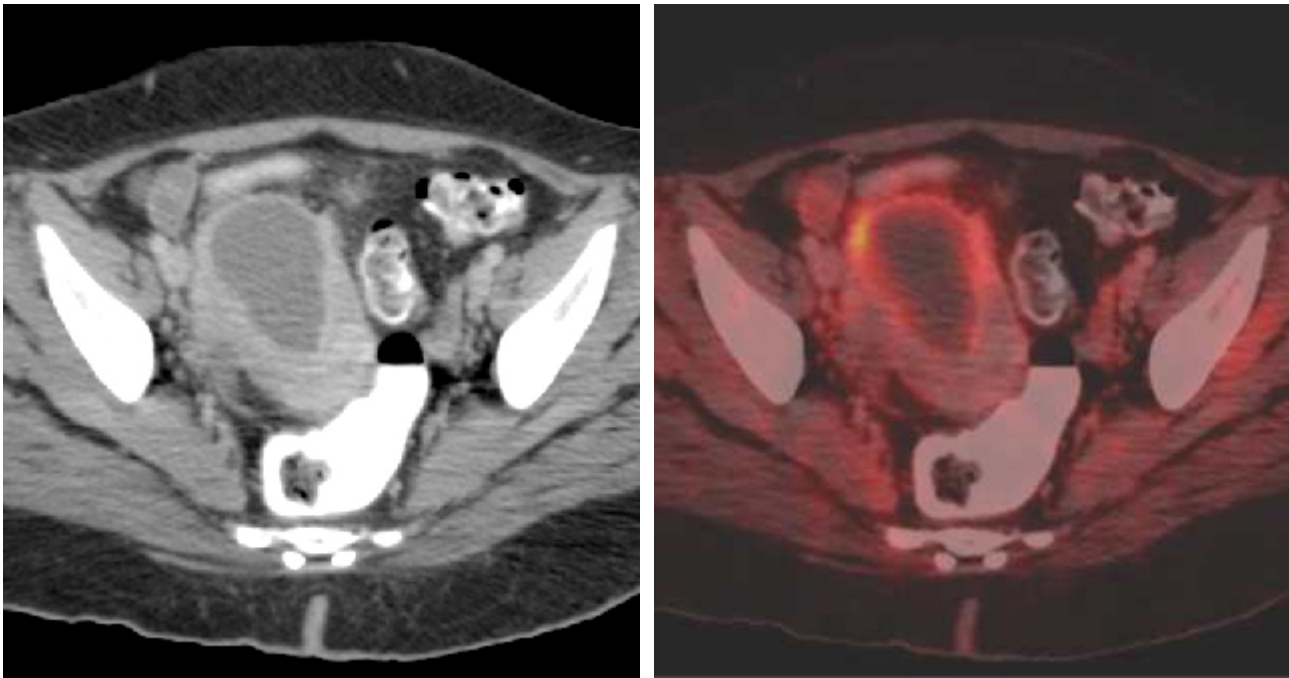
FDG avid hypermetabolic lesion involving the endometrial cavity favour persistent active diseases
